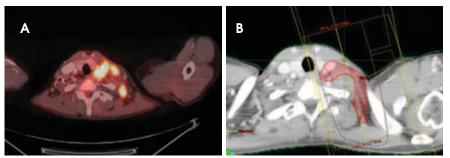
(A) FDG-PET/CT for early-stage breast cancer with isolated medial and posterior-lateral SCLN recurrence following breast conservation surgery, with (B) treatmentplanning CT highlighting suggested SCLN field extension.
